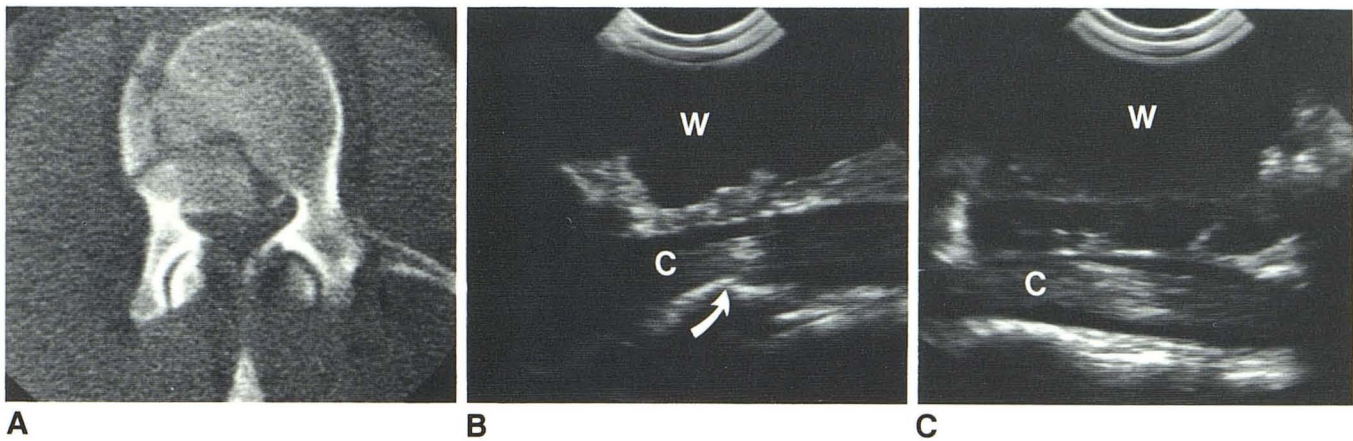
Case 2. A, Burst fracture involving mainly right side of vertebral body of T12 with bony displacement into spinal canal. B, Intraoperative sonogram. Spinal cord (C) is scanned through saline path (W) showing displaced fracture of posterior part of T12 (arrow). C, Postreduction sonogram of same
